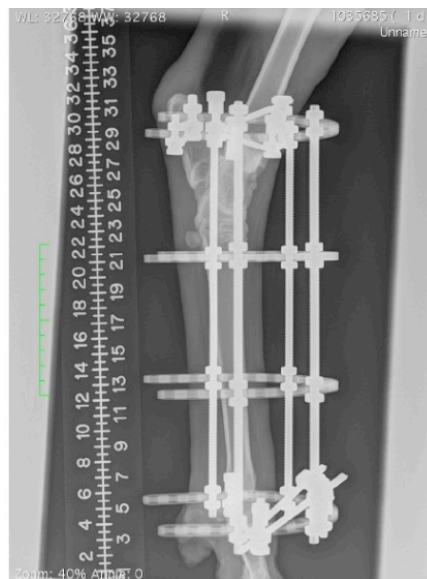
Radiograph of ex-fix placed across the hock joint to lower bone quality.
